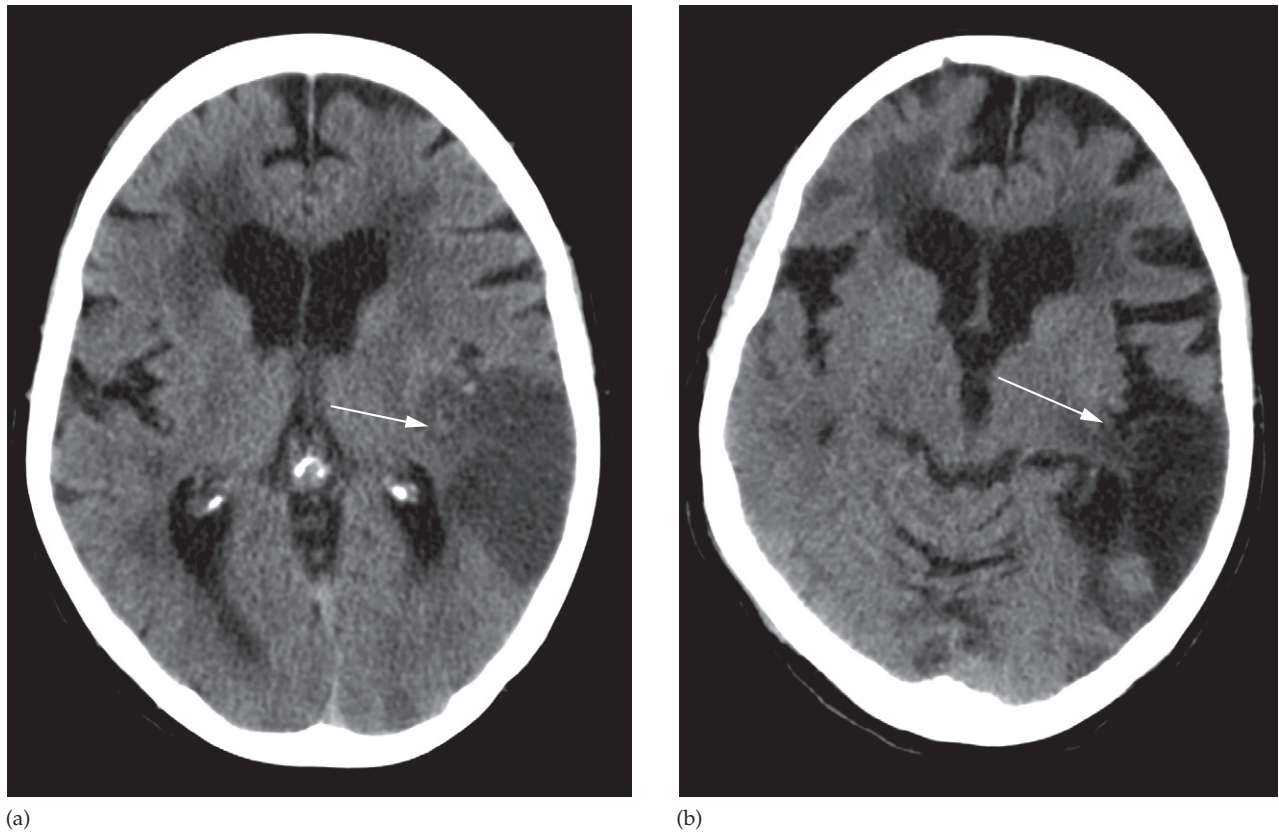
Cerebral infarction. (a) Initial CT scan a few hours after the onset of symptoms showing low attenuation in the posterior cerebral artery territory with swelling causing effacement of the local sulci (arrow). (b) CT scan a month later showing low attenuation gliotic change in the same territory and atrophy causing localized expansion of the lateral ventricle and widening of the sulci (arrow).
